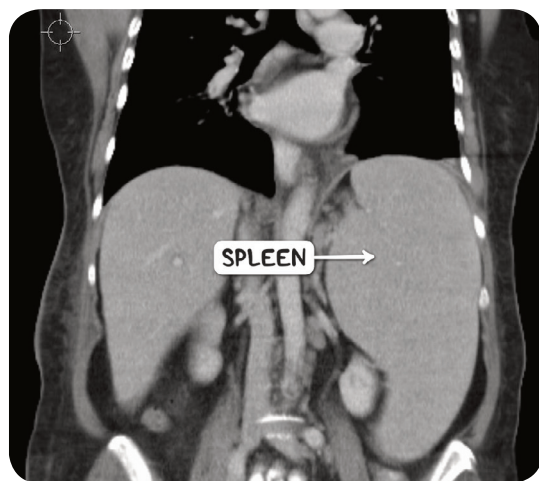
A CT scan in the coronal plane demonstrating splenomegaly as a consequence of chronic lymphoid leukemia.
